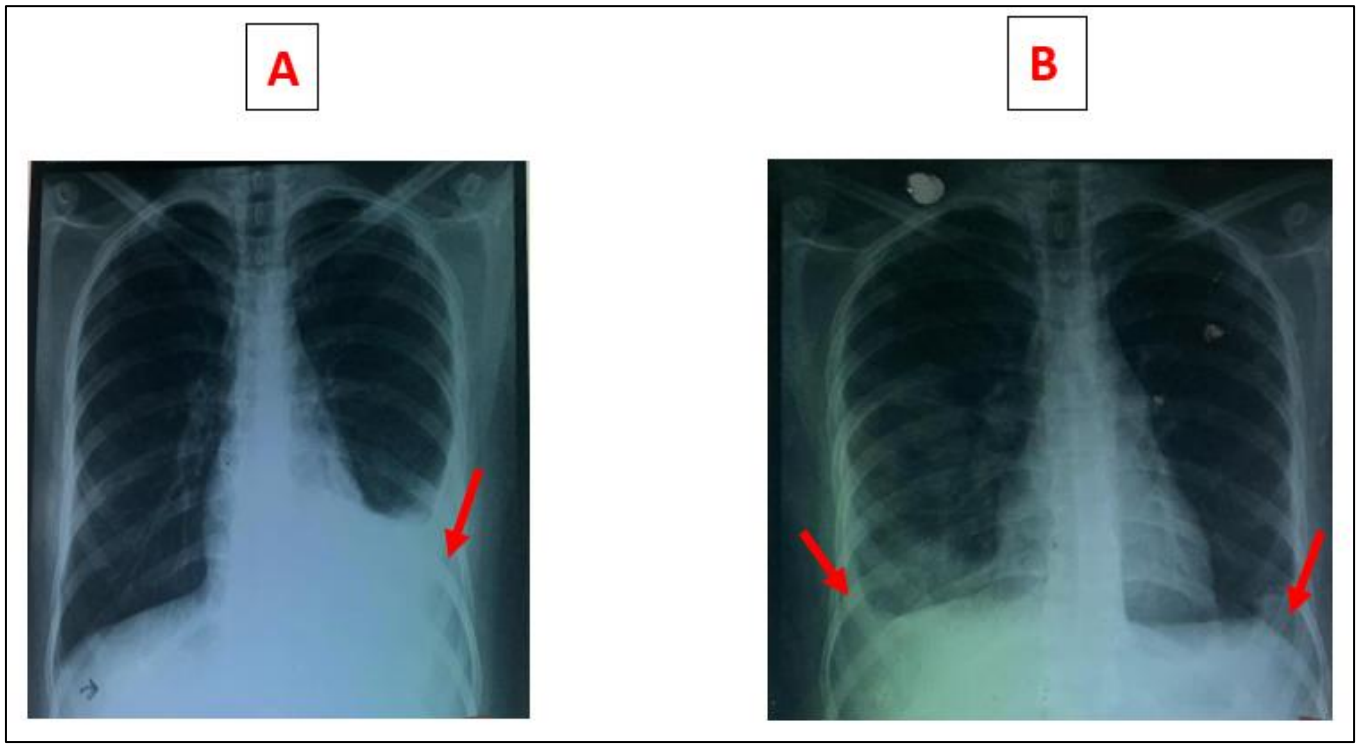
(A) Chest X-ray (frontal view) at the time of TB diagnosis: showing a dense homogeneous opacity with a watery tone in the left basithorax, obliterating the left diaphragm dome and the corresponding pleural recesses, with a heterogeneous opacity above. (B) Chest X-ray on day 52 of treatment: Bilateral alveolar opacities, predominantly in the subpleural regions (migratory pattern).
